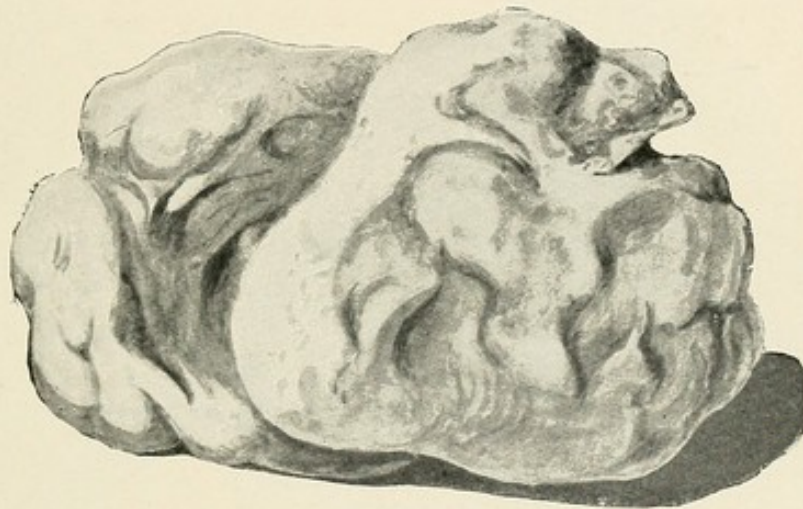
Extirpated tumours (*cf.* X-ray picture, fig. 84).
